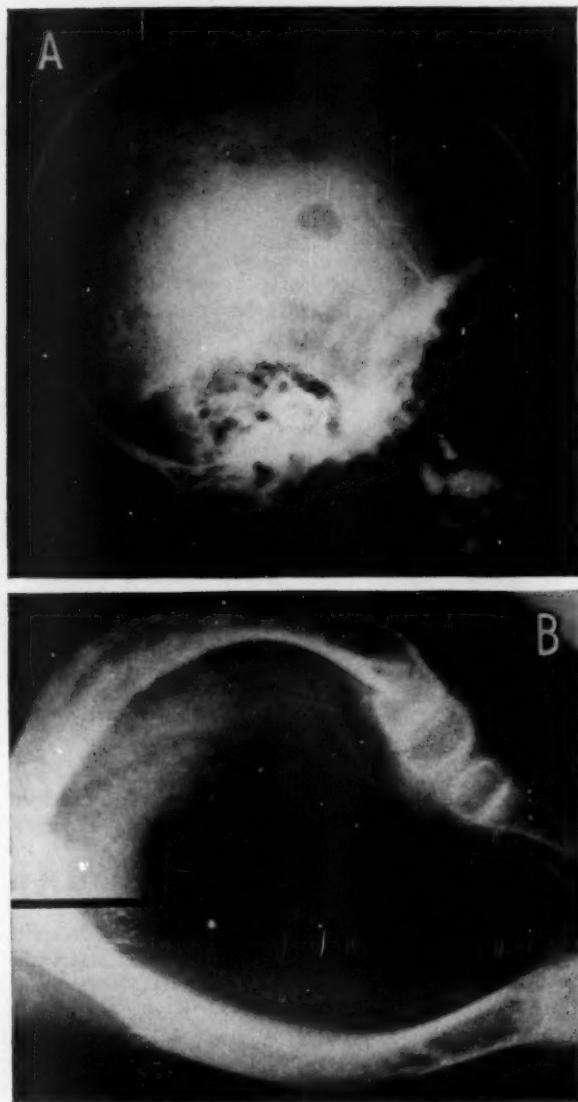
A*, roentgenogram of the skull revealing punched-out areas of thinning bone. *B*, roentgenograms of the femurs (right above, left below), showing bowing and cystlike rarefaction of bone.
